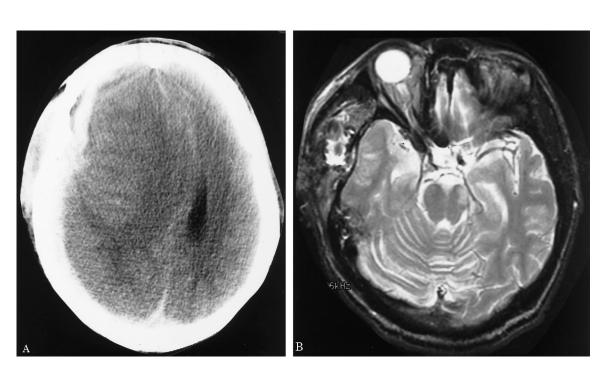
(A) Axial noncontrast head CT demonstrates an acute right-sided subdural hematoma with midline shift. (B) Kernohan's notch is shown on T2-weighted axial MRI. A hyperintense region is located in the contralateral left cerebral peduncle, giving rise to the ipsilateral hemiparesis.
